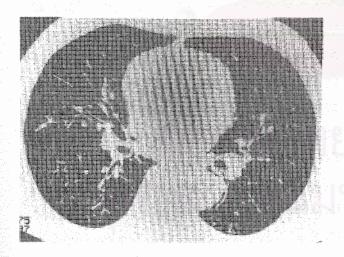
Expiratory HRCT of lower lung of case 2 shows diffuse centrilobular nodules and branching linear opacities throughout both lungs, typical of the 'tree-in-bud' pattern of small airway disease. Dilatation and thickening of small bronchi and bronchioles are observed. This expiratory film also shows multiple areas of air trapping.
